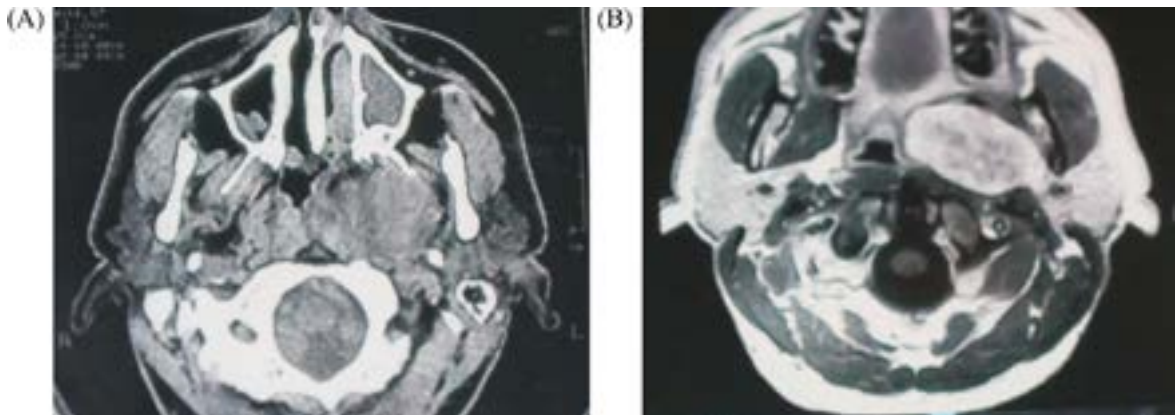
(A) CT and (B) MRI (T2 axial), a 5 cm tumor occupying the middle compartment of the PPS in continuity with the deep lobe of right parotid gland.
